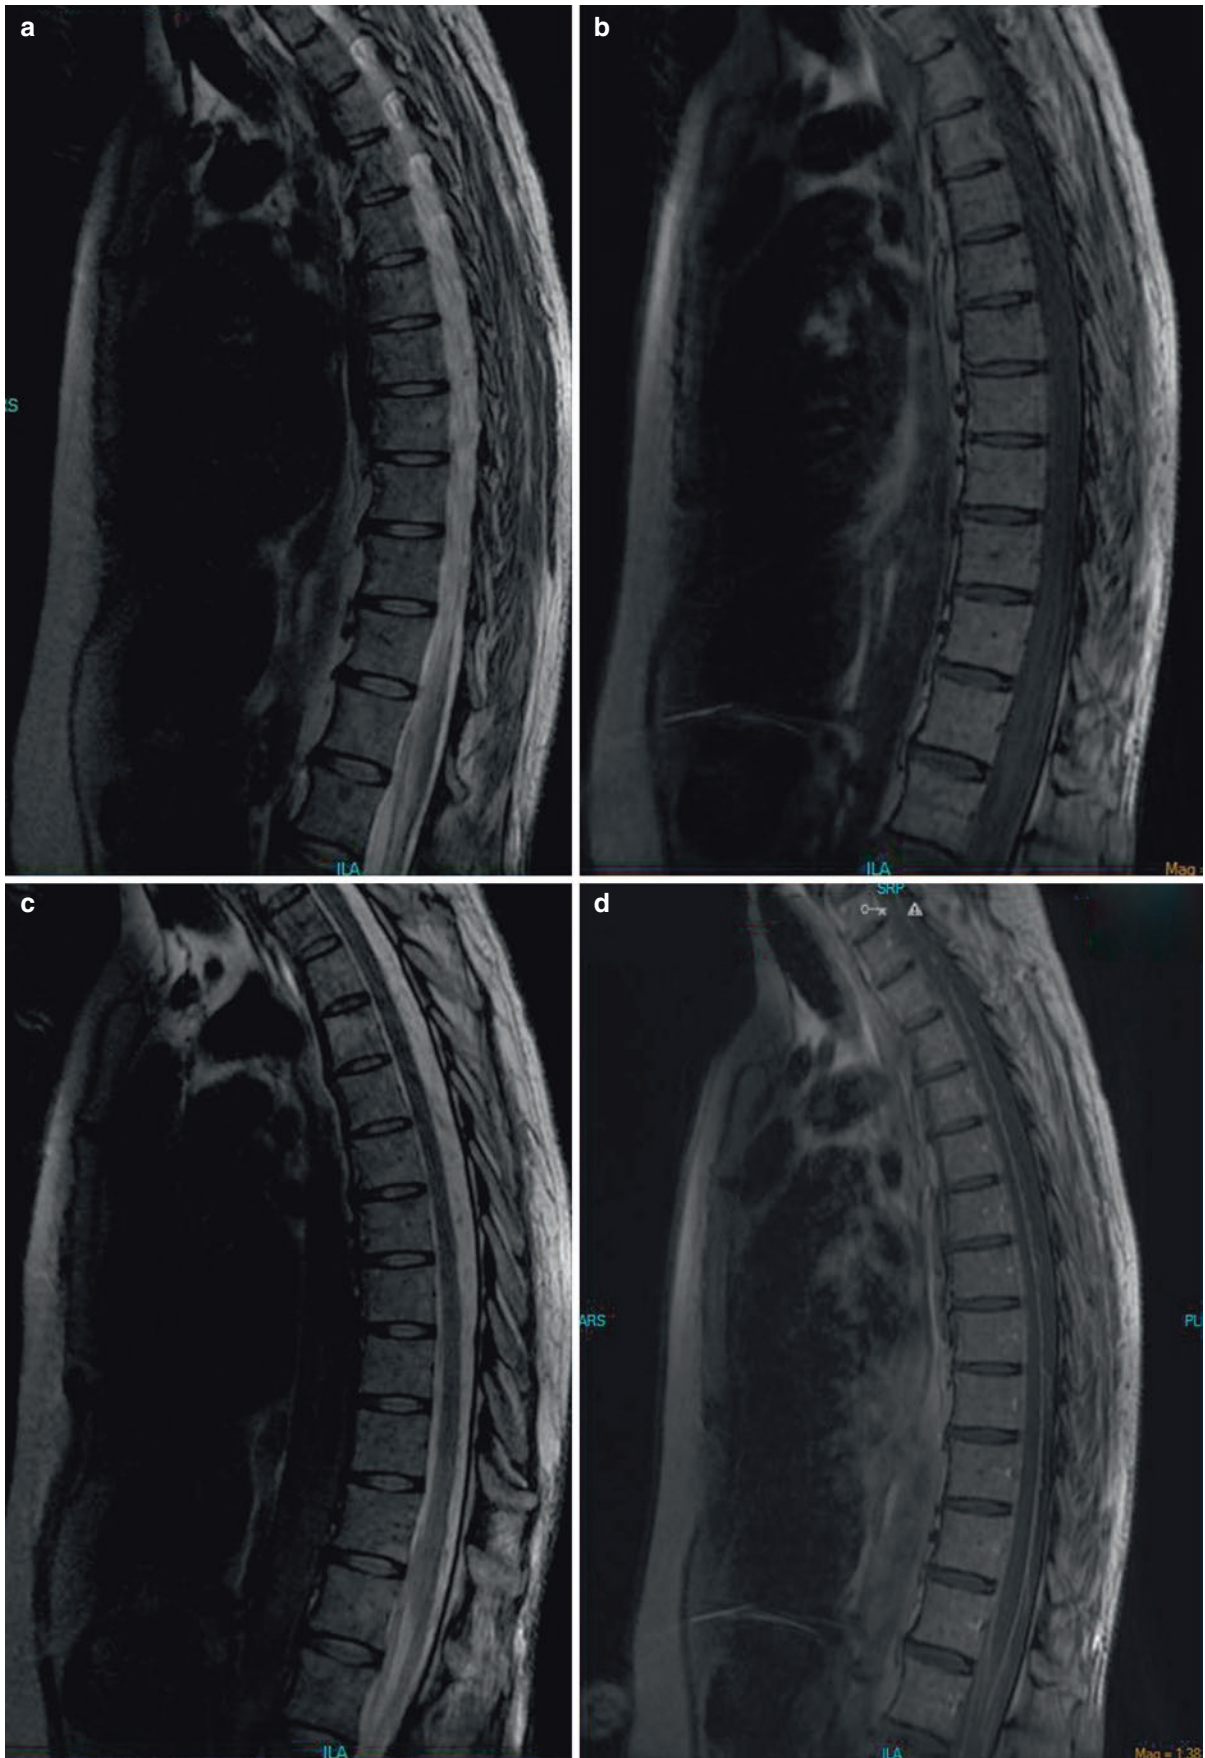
(a–e) LM metastases at t1 and t2; precontrast and postcontrast sagittal MR images
